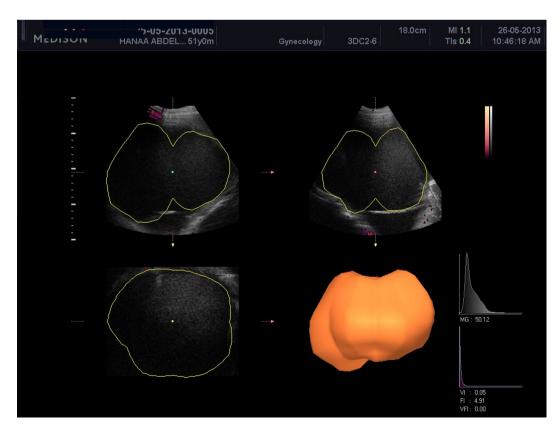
Three-dimensional power Doppler analysis of the blood flow inside the mass revealed low vascular indices.
